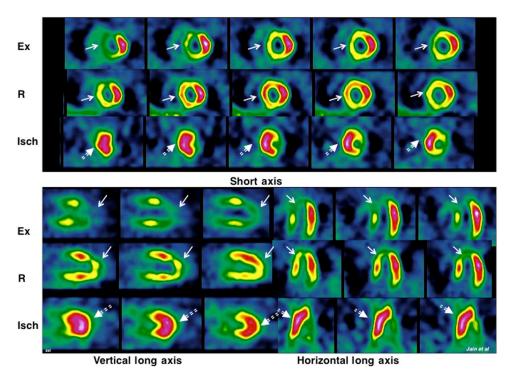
Exercise (Ex) and rest (R) ⁹⁹mTc-sestamibi and exercise ¹⁸FDG (Isch) images of an 67-year-old man with angina and no prior myocardial infarction. There is a large area of partially reversible perfusion abnormality involving the septum, anterior wall, and apex (small arrows). Intense ¹⁸FDG uptake is present in these areas (solid arrowheads). Coronary angiography showed 90% stenosis of the left anterior descending coronary artery and a 60% stenosis of the left circumflex artery. *Source: Reproduced with permission from Ref.* [54].
